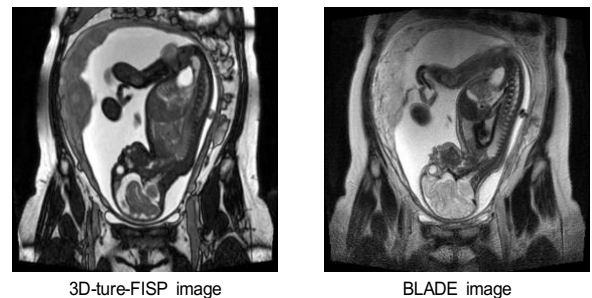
Fetal MRI images
